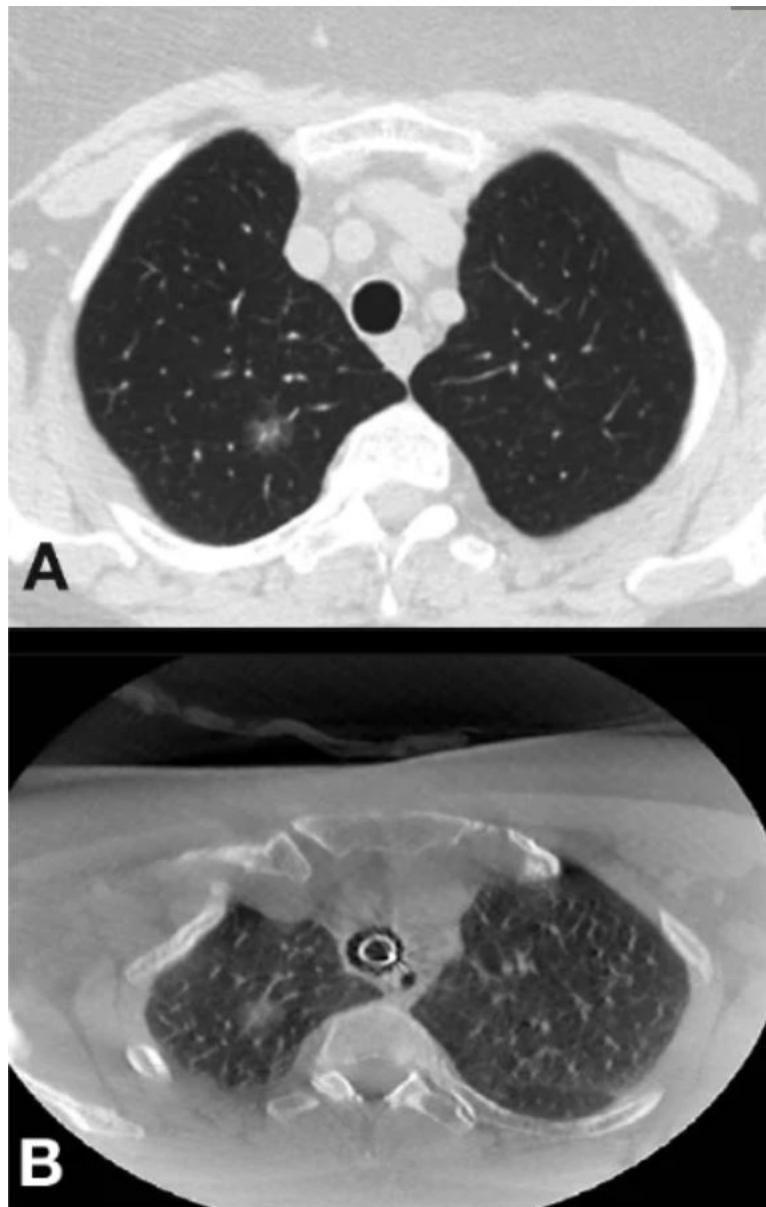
This figure shows a comparison of cone beam (CBCT) and a standard CT image of the same patient. Image A is a CT image and image B is a CBCT image [6].
